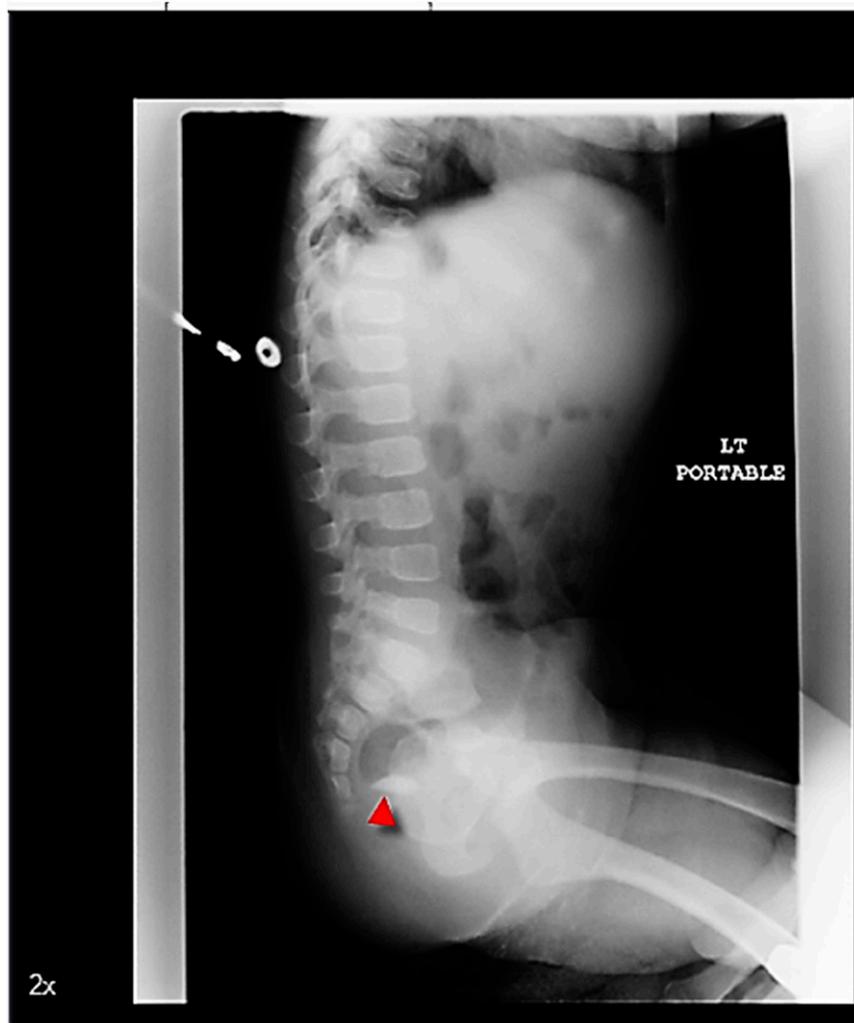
Left lateral radiograph of the pelvis revealed FB migration into rectum (day 3 of admission).
